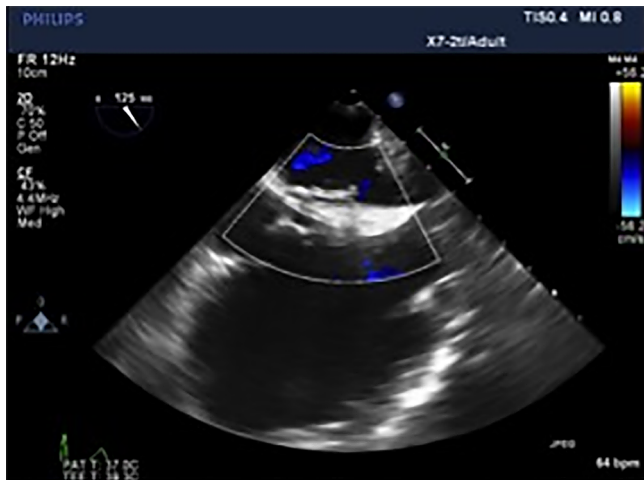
Transesophageal echocardiogram of the Cardioform device with color Doppler.
